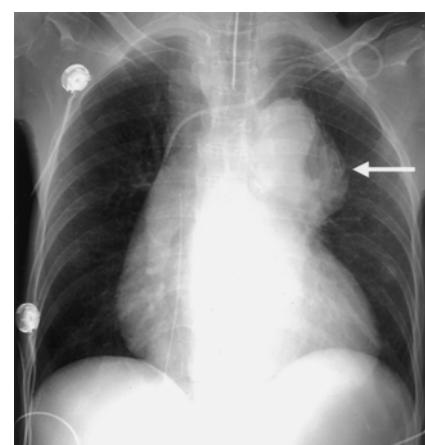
Chest radiography on admission showing cardiomegaly and dilation of the aortic arch (arrow).
